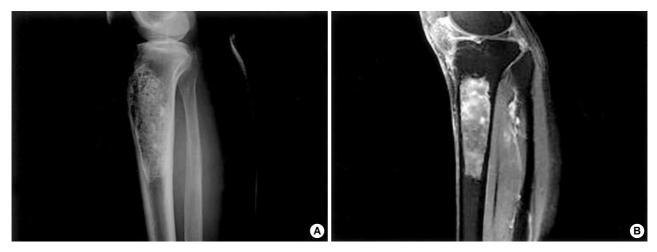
(A) Anteroposterior radiograph of the left tibia reveals an about 10 cm-sized lytic and radiolucent lesion, which showed irregular sclerotic rim, thinning of the cortices, internal ground glass appearance, and multiple irregular nodular calcifications. (B) T2-weighted MR image shows a relatively homogeneous high signal intensity and multiple internal irregular nodular enhancement along the margins of calcification and trabeculations.
